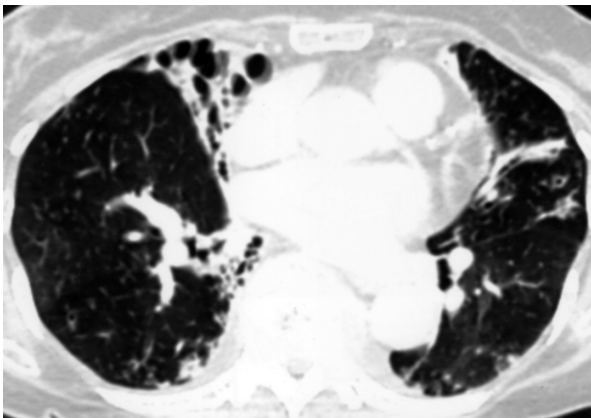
Chest CT showed bronchiectasis of both lower lobes, with cicatrization atelectasis, and multiple ill-defined opacities and infiltrates.
